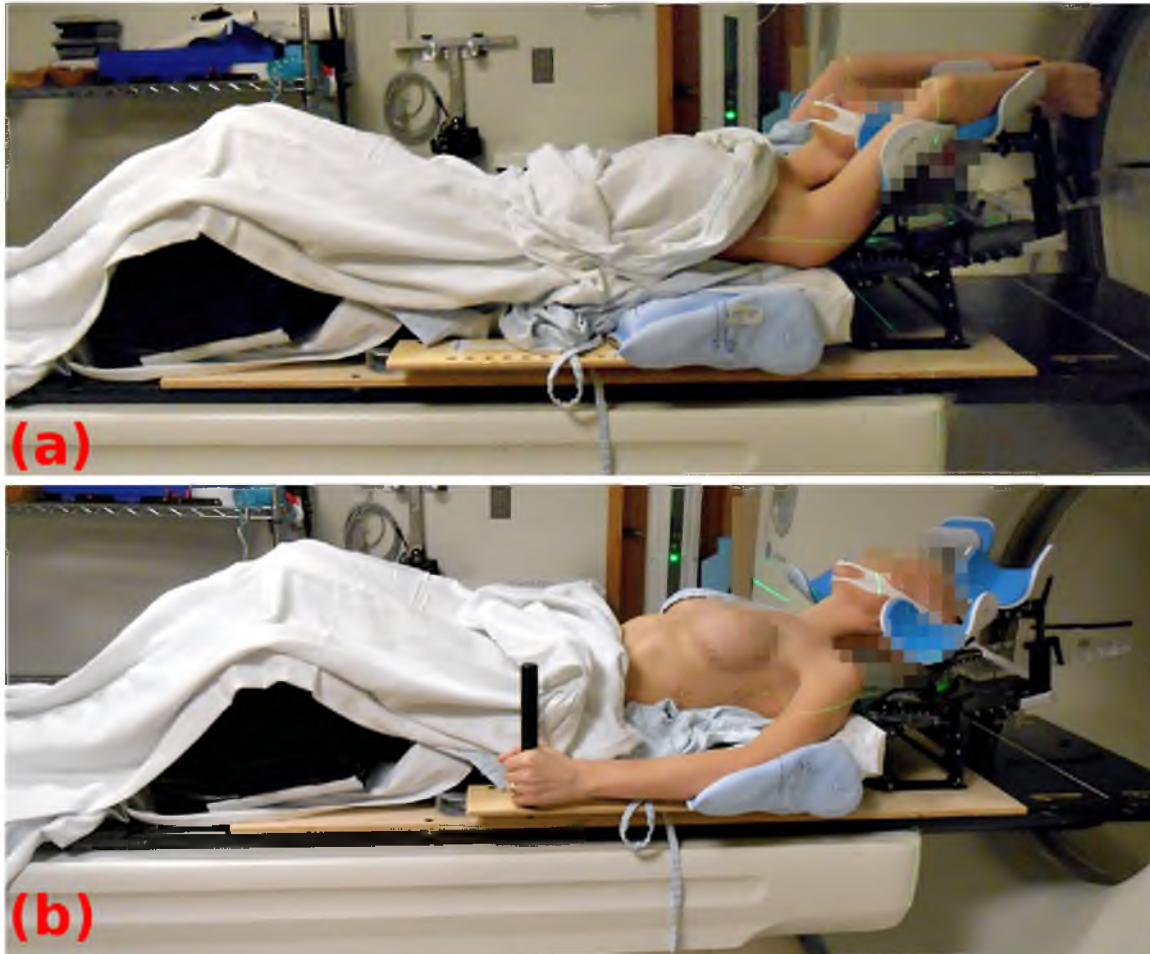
PMRT patient setup at the time of CT scan: (a) conventional arms up setup position, (b) novel arms down setup position; in both cases, a chin strap and hand grips are used to ensure better reproducibility of the setup position.
